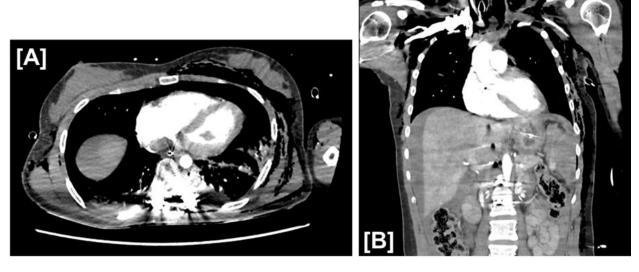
Axial [A] and coronal [B] slides of CT scan performed on admission (Day 0).
